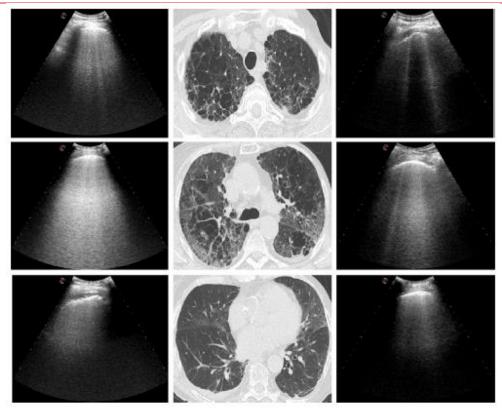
Comparison between HRCT and lung US according to LUSCOP protocol. From top to bottom: upper, medium, and lower fields are shown both in HRCT slices and in the corresponding right and left lung US. HRCT shows diffuse pulmonary emphysema mostly in upper and medium fields, associated with COVID-19 bilateral dorsal, subpleural ground-glass opacities, and consolidations. In the upper fields, B-lines at the lung US correspond to areas of mild interstitial involvement. In the middle fields, lung ultrasound shows confluent B-lines with pleural thickening. In the lower fields, pleural effusion is detected by lung US in the right side, associated with pleural thickening and irregularity; the left lung US shows a predominantly A-pattern corresponding to relatively spared parenchyma.
